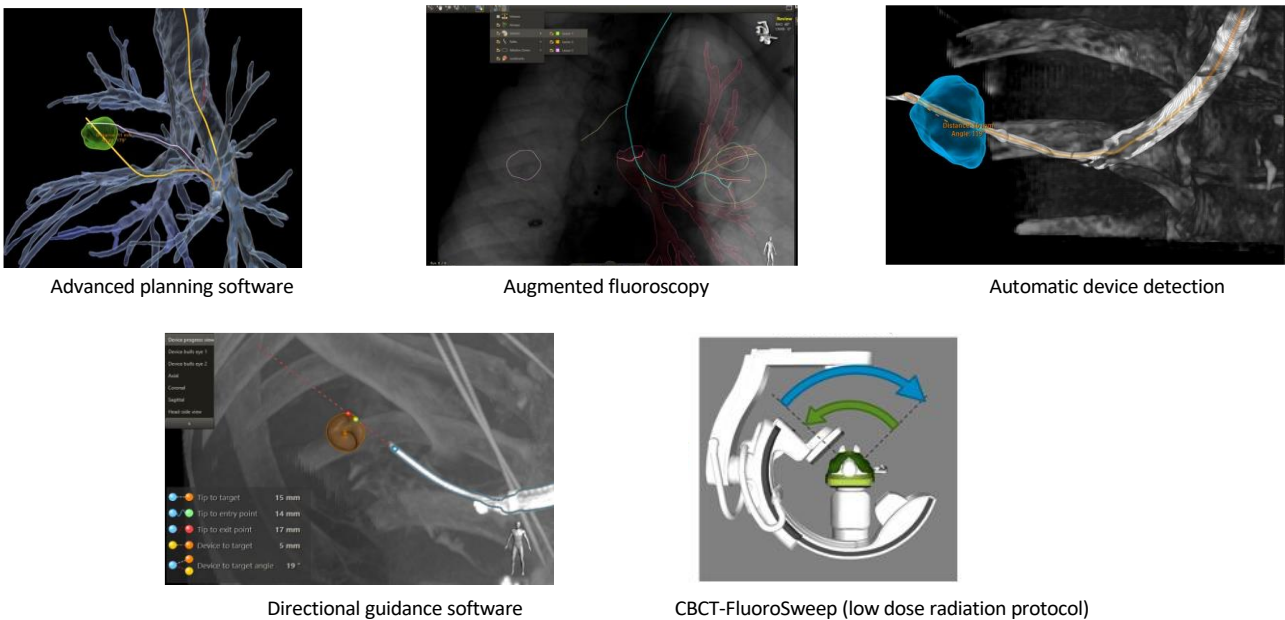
Software features of the AirWaze investigational device (version 1.1), namely advanced planning software (top left), augmented fluoroscopy (top middle), automatic device detection (top right), directional guidance software (bottom left), and CBCT-FS imaging protocols (bottom right).
